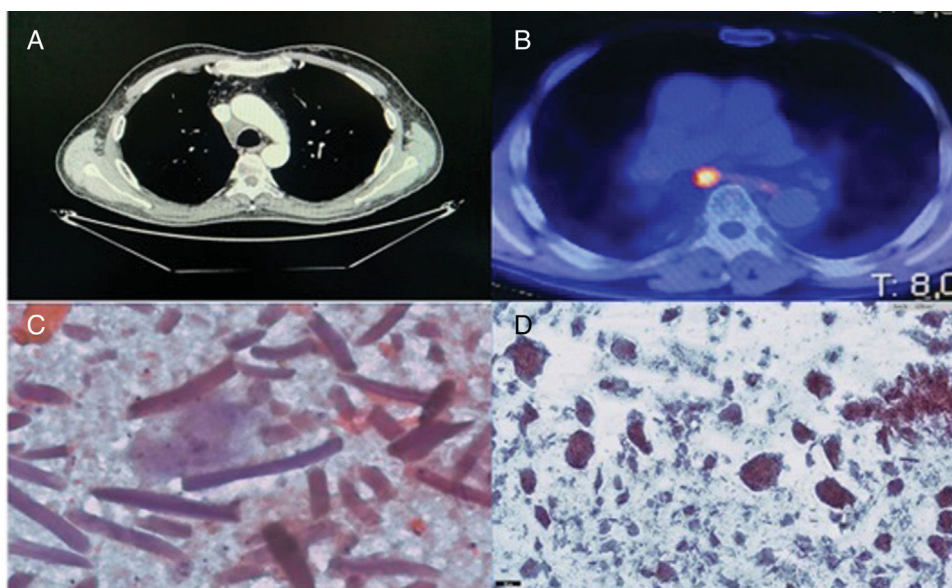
(A) Chest CT scan showing enlarged nodal station 4R. (B) PET/CT with increased metabolism in subcarinal adenopathy. (C) Giant cells with birefringent material (400×) from the first case. (D) Birefringent amorphous material under polarized light from the second case.
